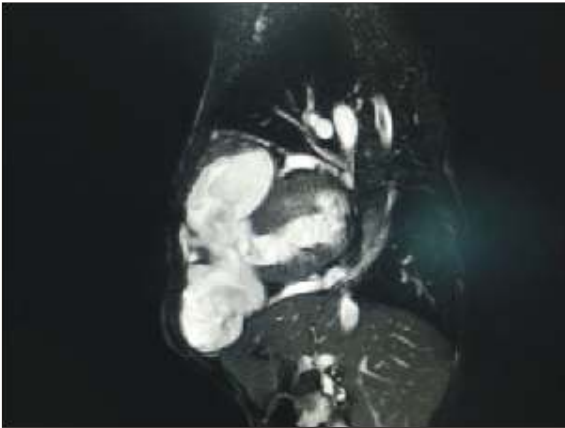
Cardiac MRI showing large, irregular, lobulated aneurysm displacing the abdominal viscera
